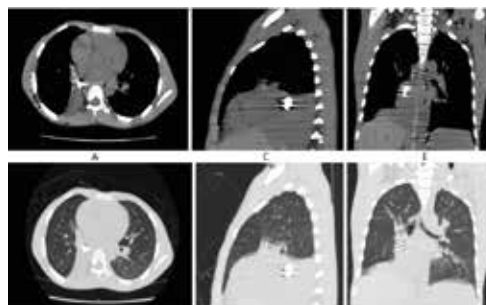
Non-contrast Chest CT; axial (A and B), sagittal (C and D) and coronal (E and F) planes in mediastinal and lung windows respectively showing a hyperdense object of metallic density (HU 2032) with streaky artifacts impacted in the terminal part of the right bronchus intermedius with associated multiple segmental right lobe collapse (medial segment of middle lobe, apical, posterior basal/medial segments of lower lobes).
